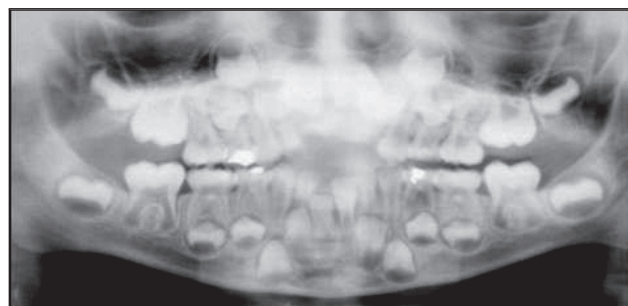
Orthopantomograph: no numerical or morphological dental anomalies were found in the radiographic examination
